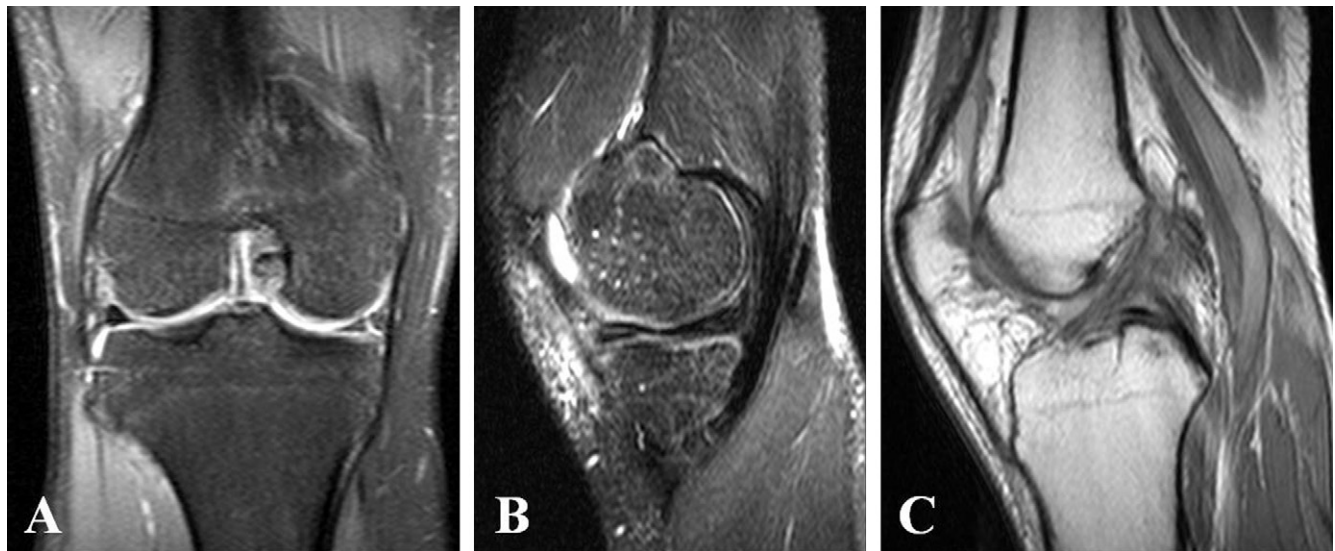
A, B. MRI showed combined horizontal and vertical traumatic tear of medial meniscus. C. Sagittal MRI showed complete rupture of ACL at the femoral attachment site.
